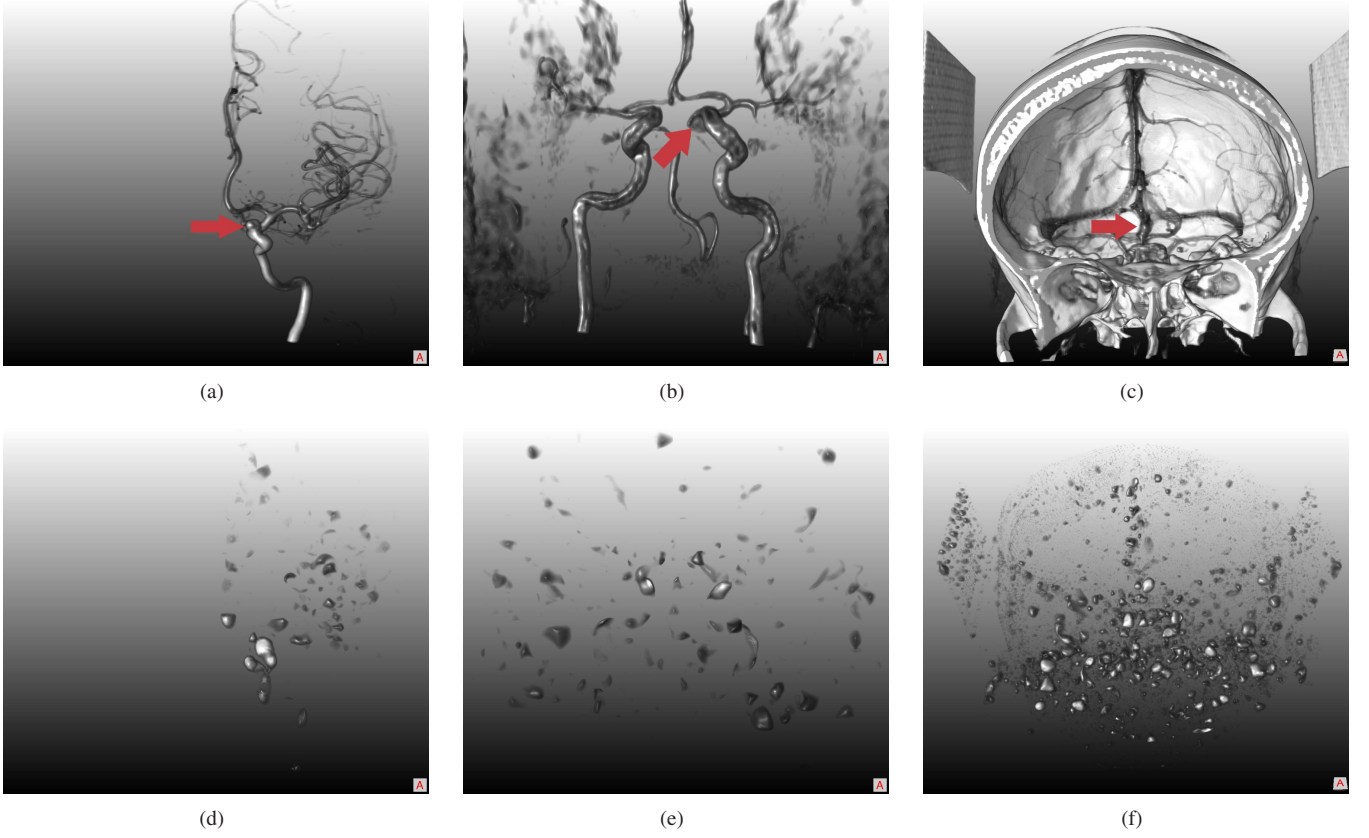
Volume renderings of examples of (a) 3D-RA, (b) MRA and (c) CTA. The aneurysms are marked by arrows. The corresponding blobness-filtered volumes are shown in (d)-(f).
